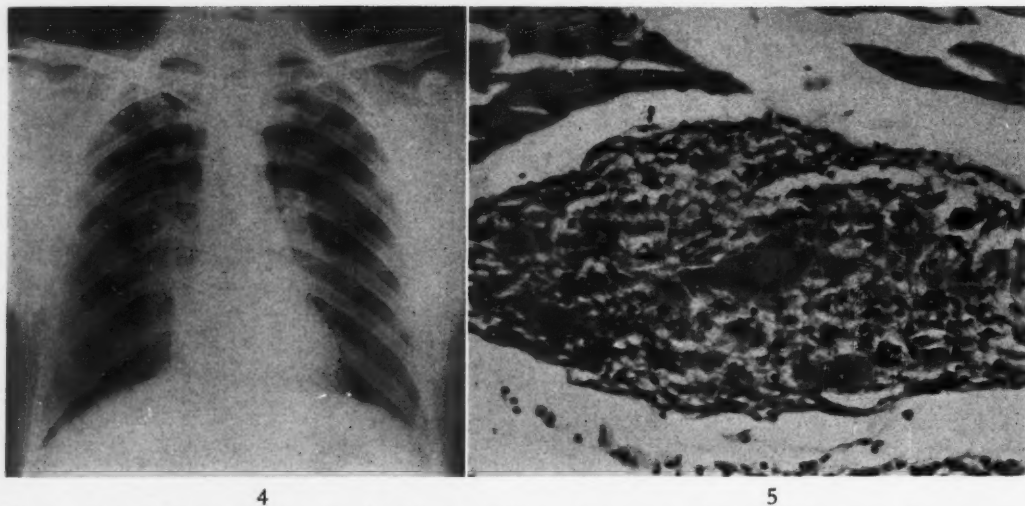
Case II. X-ray of chest showing bilateral hilar enlargement with a nodular, granular appearance in both lung fields.
